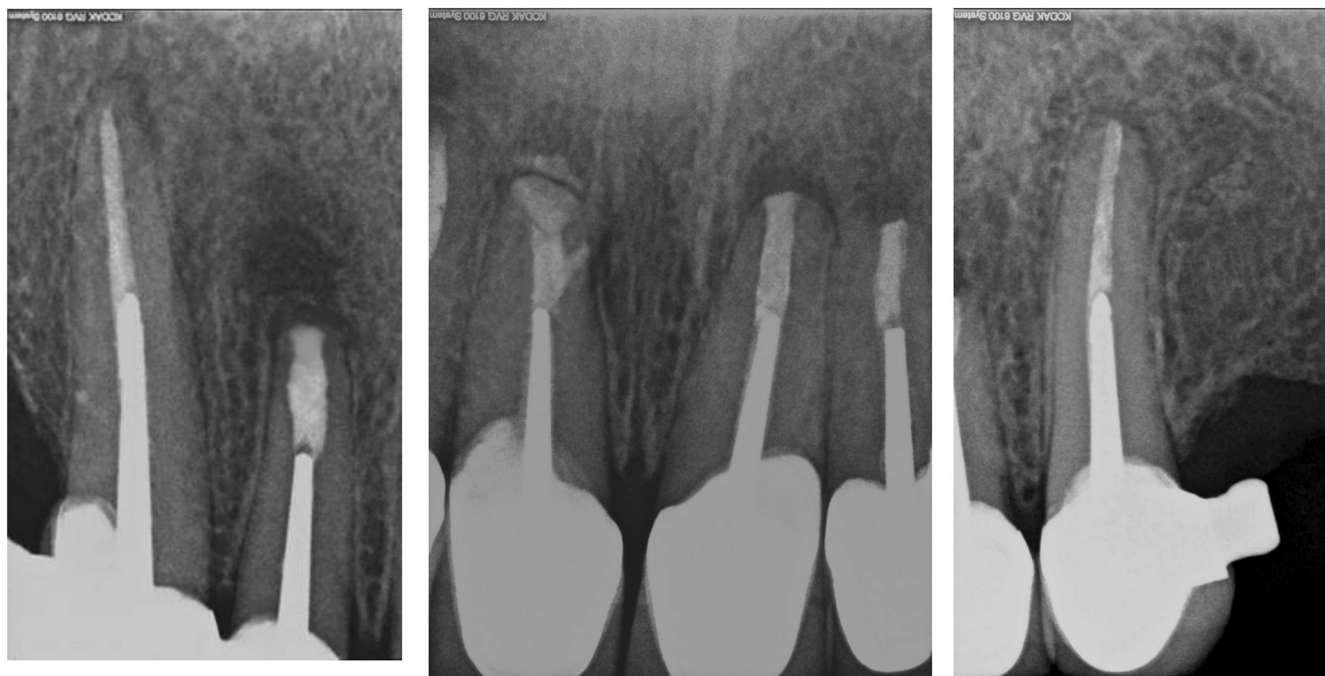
Periapical radiograph showed healing of periapical lesion of the of maxillary anterior teeth: 1 year after treatment.
